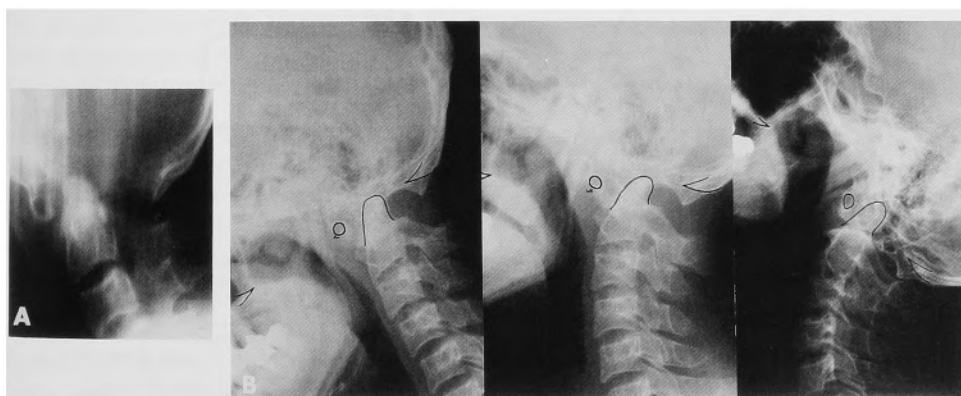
A: Tomography of the crano-cervical junction. Assimilation of the atlas was demonstrated. B: The lateral views of the spine X-rays. The distance between the posterior aspect of the anterior arch of the atlas and the anterior surface of the odontoid process was 7 mm in the anteriorly-flexioned position and 8 mm in the neutral position. An X-ray film taken in the posteriorly-flexioned position demonstrated that the tip of the odontoid process was situated 6 mm above Chamberlain's line and 7 mm above MacGregor's line.
